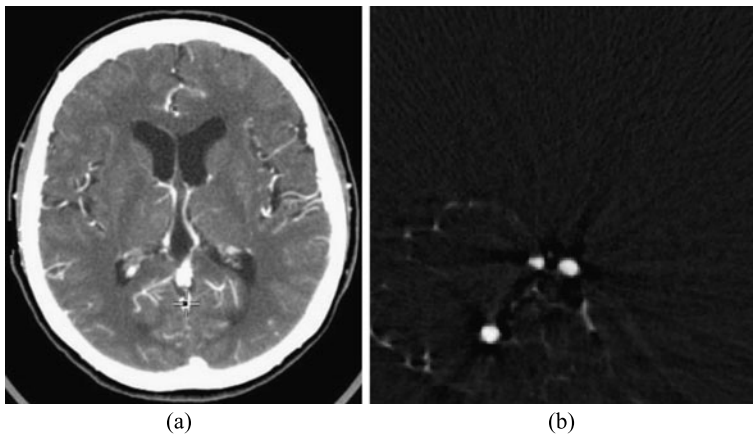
CT angiography (a) shows contrast-enhanced vessels. While showing also tissue in the context, vessels are more difficult to detect than in reconstructed DSA images (b)
